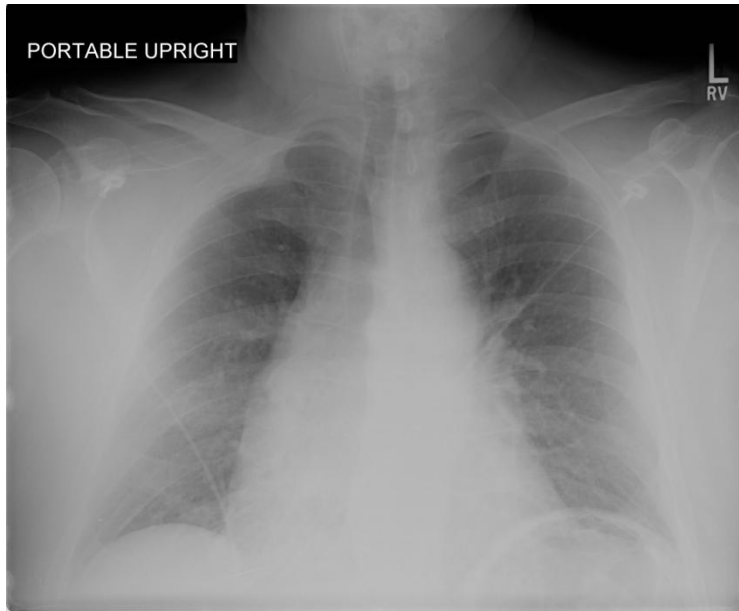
Admission chest X-ray.
